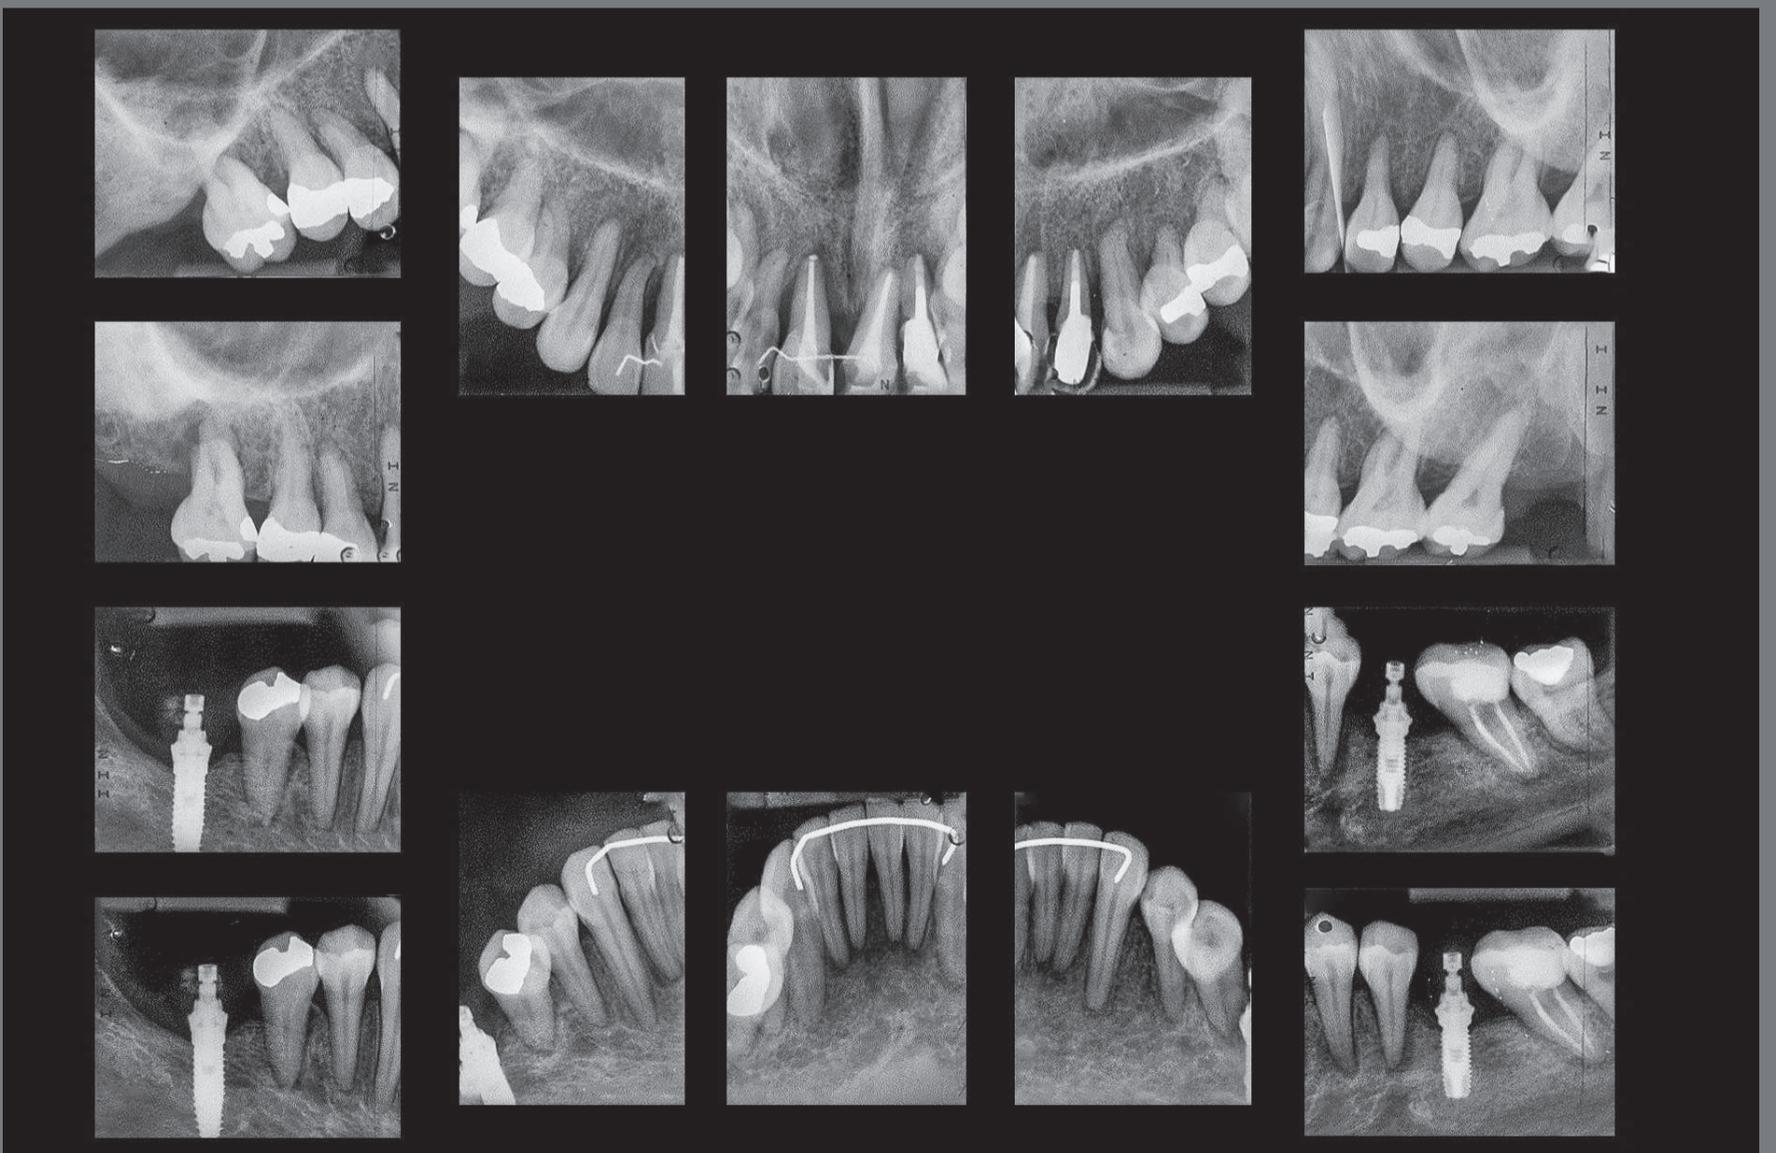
Periapical radiographs at the end of treatment.
